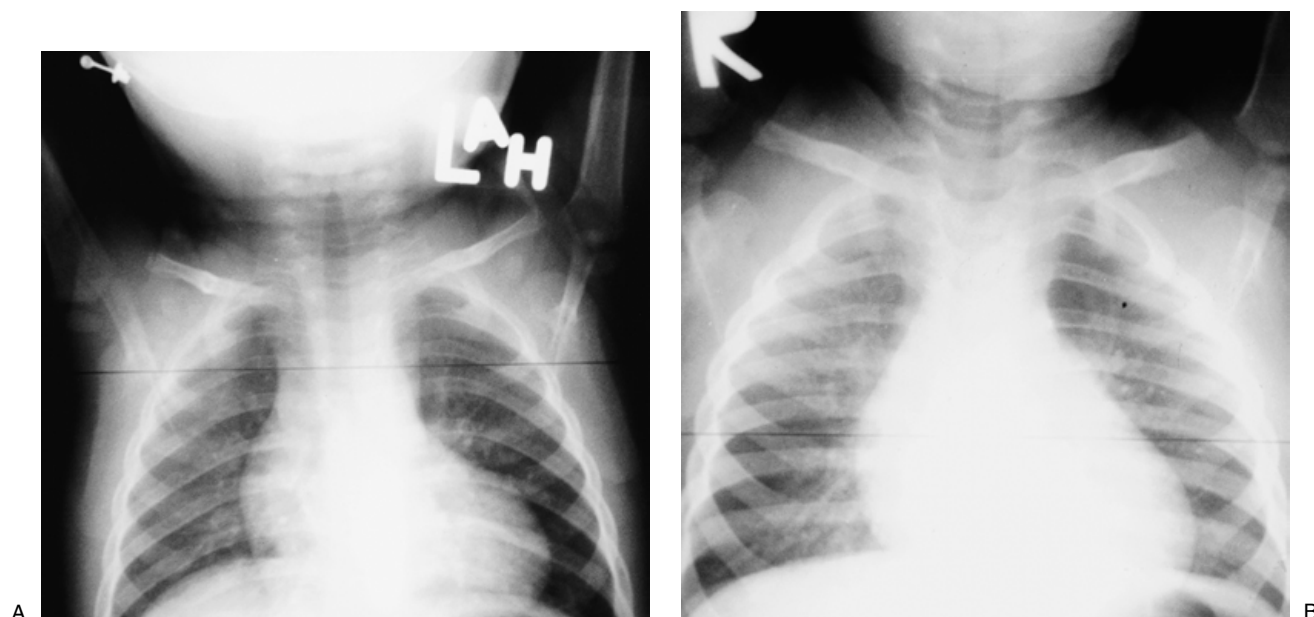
(A) This x-ray image shows the tracheal air column of a normal infant. (B) This x-ray image demonstrates a narrowing of an infant's tracheal air column due to edema of the trachea during an episode of croup (the "steeples" sign).
